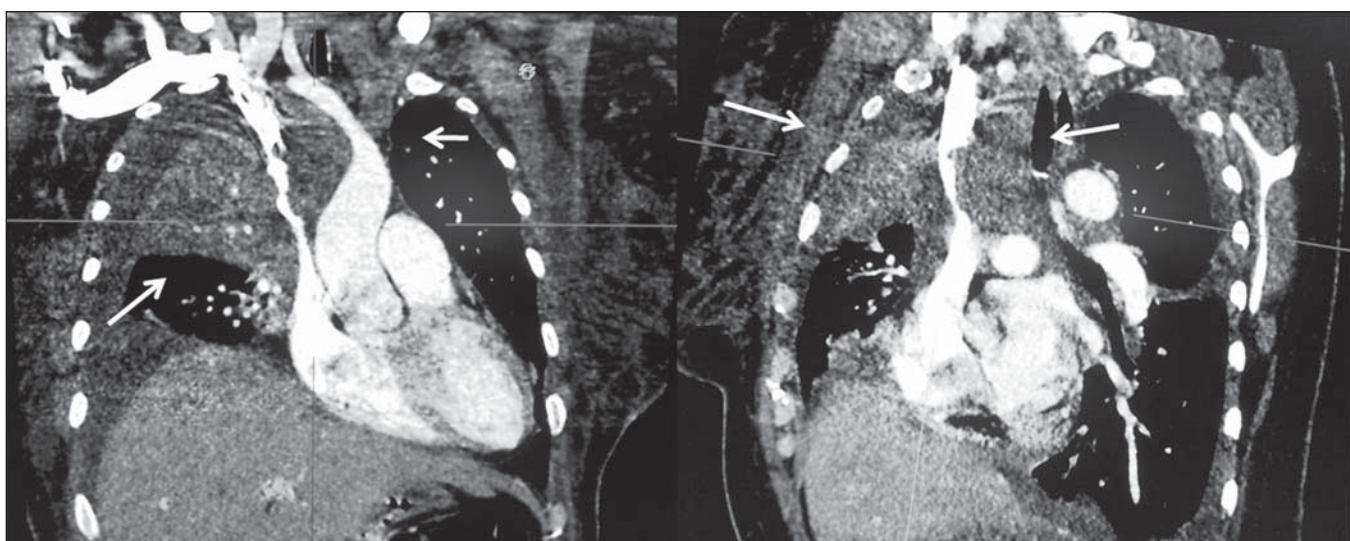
Contrast-enhanced chest computed tomography, coronal and sagittal sections. Ill-defined mediastinal mass with invasion of the superior vena cava (arrows).
